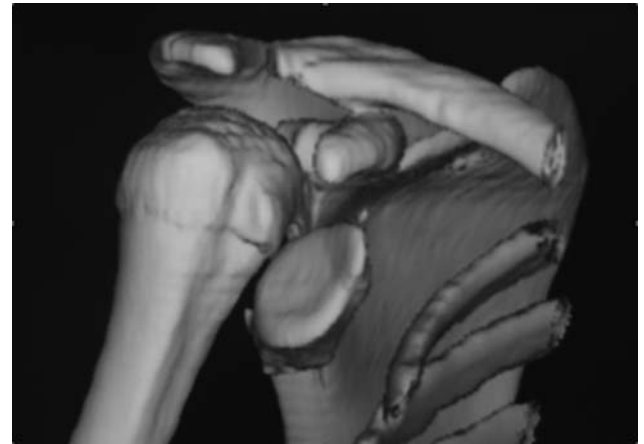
Shoulder CT, 3-D reconstruction showing the glenoid fossa fracture dislocation with full anterior and inferior displacement, and the humeral head sitting in its normal position.
